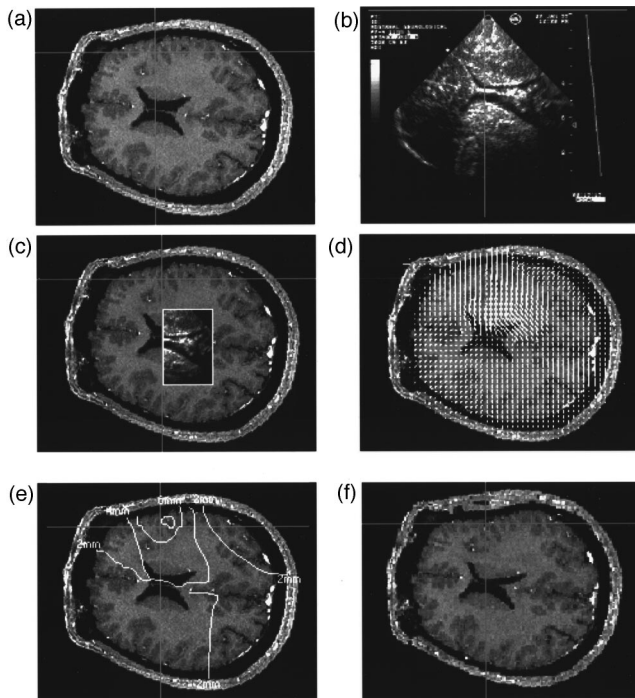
(a) Oblique MRI image oriented to match intraoperative US image (b). The image clearly demonstrates the ventricles, mid-line (falx) and the cortical surface of the brain. (b) Intraoperative US image showing compressed ventricles, but relatively stable falx. (c) ROI tool superimposing intraoperative US on the pre-operative MRI demonstrating ventricular deformation. (d) Deformation grid ($n=64 \times 64$) obtained after delineation of the ventricles and the falx from the US image, and the cortical surface obtained from the point samples. (e) Deformation magnitude image obtained from the deformation grid. (f) Deformed MRI image after application of the deformation grid.
